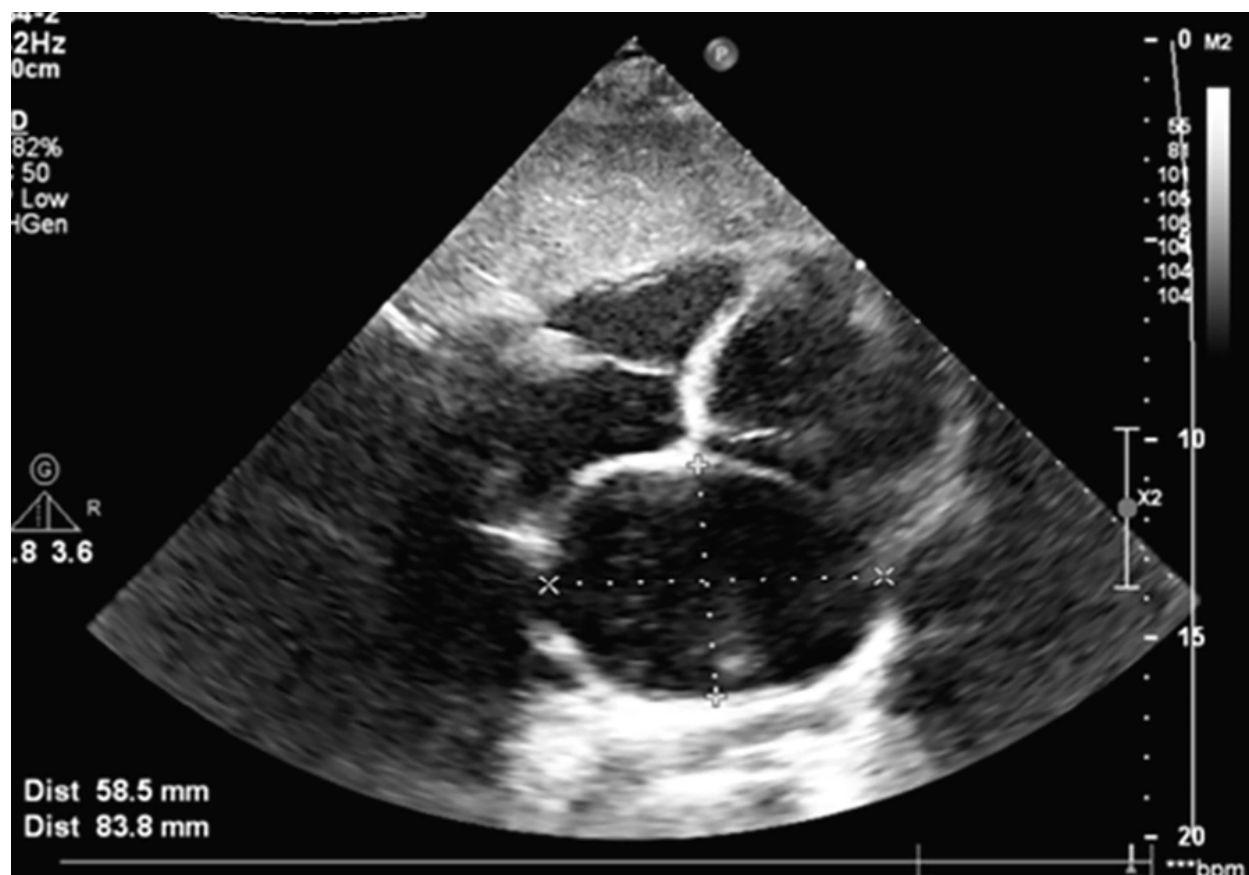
Pericardial cyst (PC) in echocardiography
